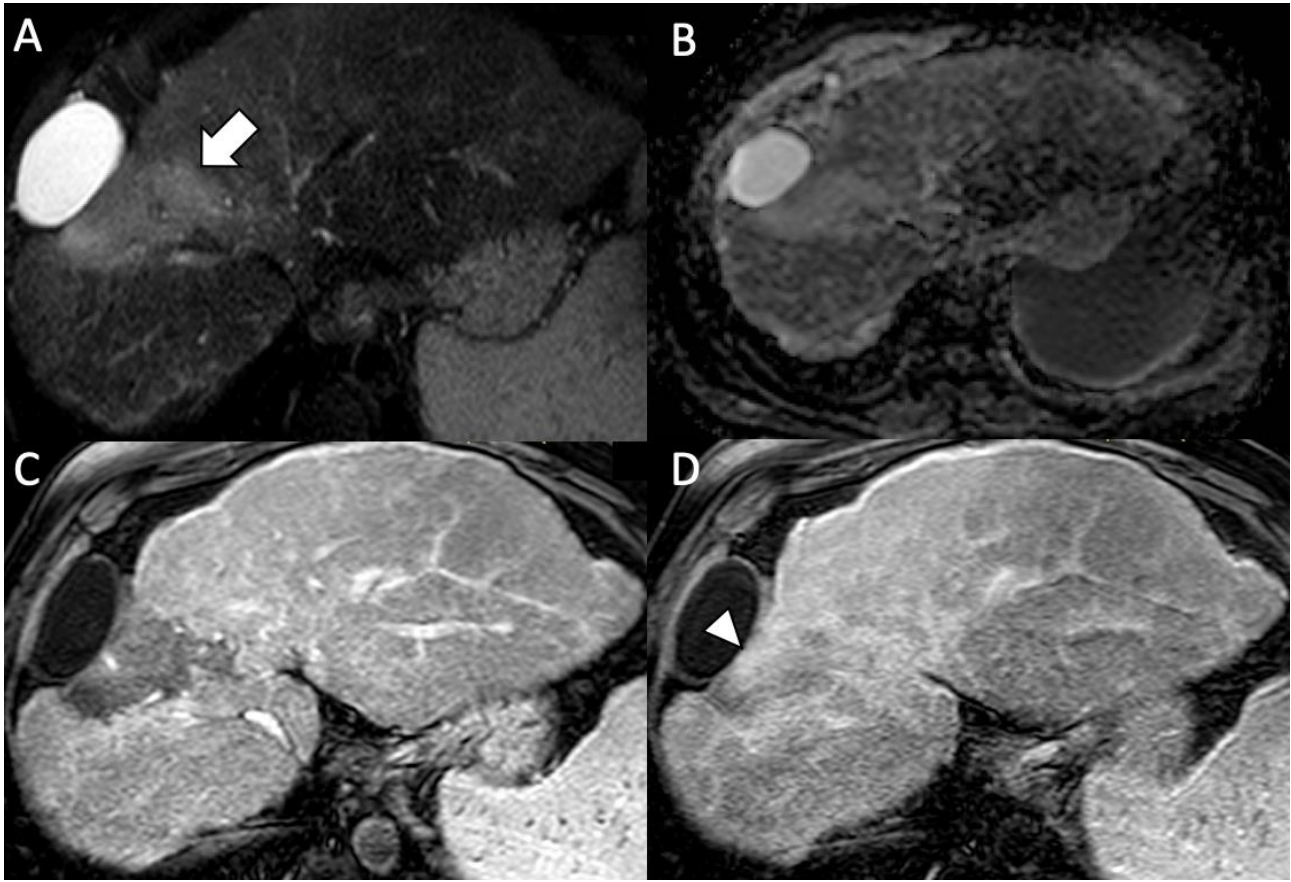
52-year-old cirrhotic man with focal confluent fibrosis. Gadoterate meglumine MRI demonstrates on (a) T2-weighted sequence a wedge-shaped hyperintense observation (arrow) in segment VIII (b) with lack of diffusion restriction on apparent diffusion coefficient map, (c) lack of enhancement on arterial phase and (d) progressive enhancement (arrowhead) at 5-minute delayed phase.
